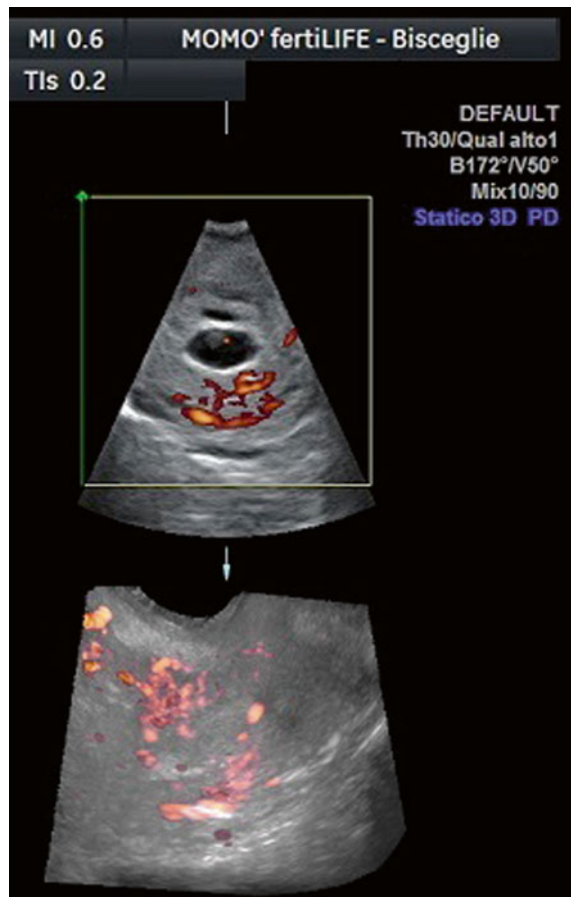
The ultrasonographic image shows the peritrophoblastic blood flow with the use of color Doppler
